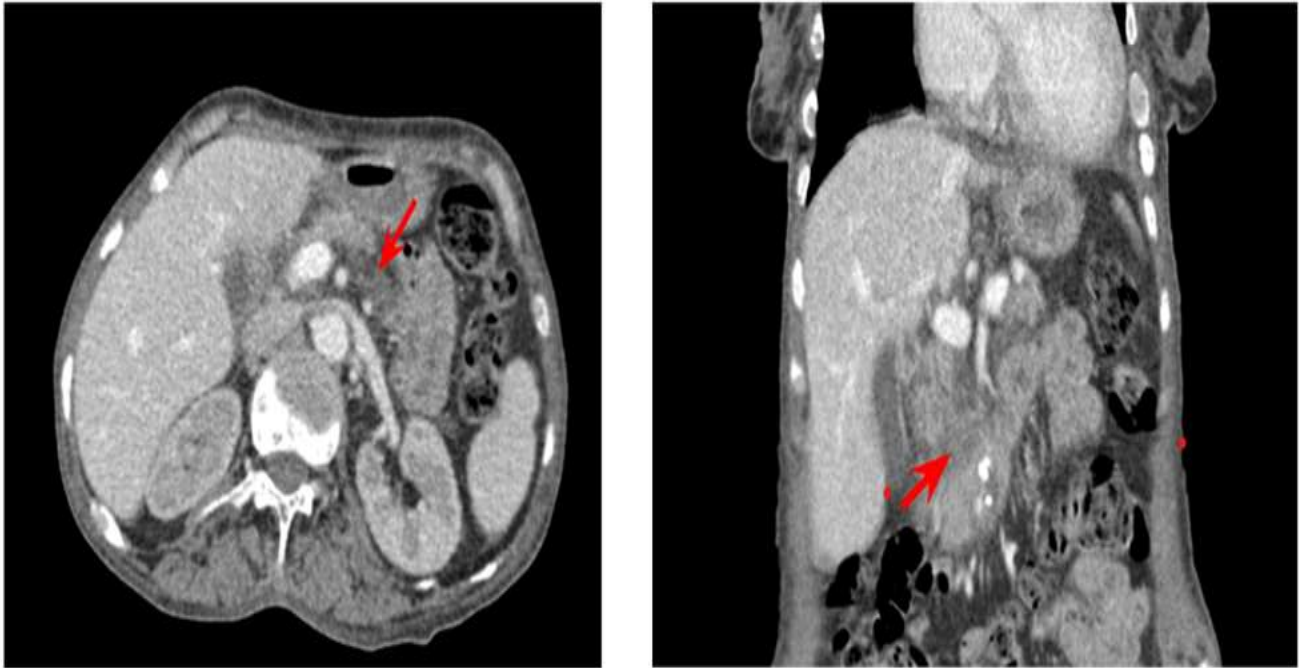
Abdominal CT revealing alithiasic pancreatitis stage C with infiltration of the peri and subpancreatic fat (red arrow).
